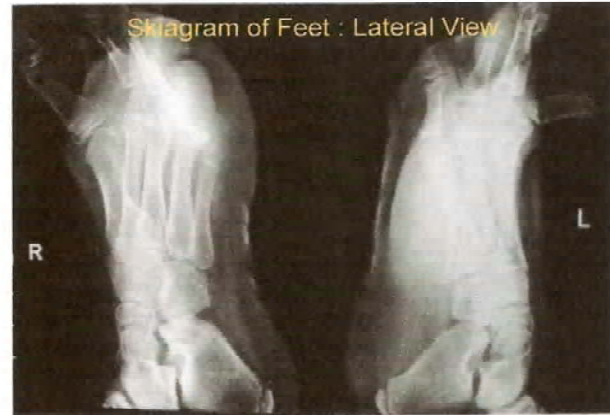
No. -2B Digital X-ray of feet - Lat. View
